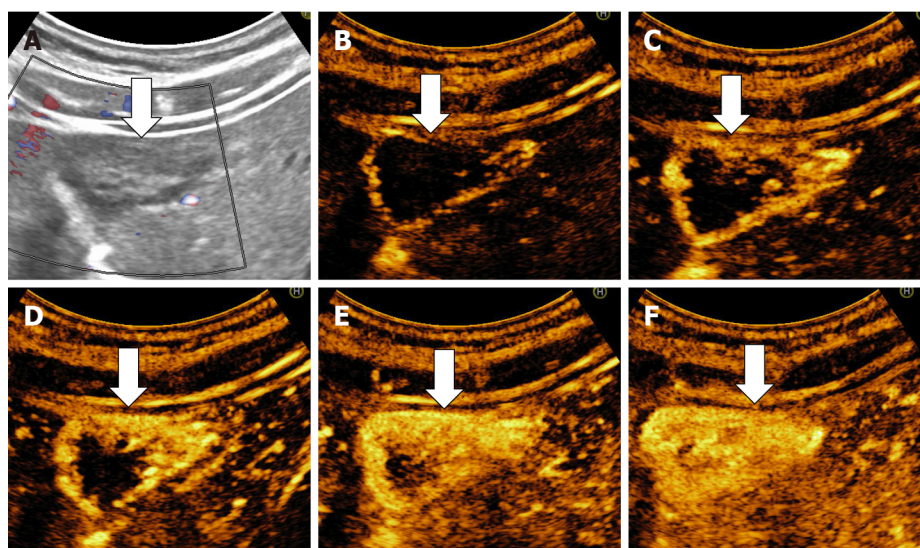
Example of hepatic hemangioma with inhomogeneous echogenicity. A: Gray scale ultrasound; B-E: On contrast enhanced ultrasound the hemangioma shows the typical peripheral nodular contrast enhancement (B and C) and centripetal fill-in (D and E); F: The mass shows strong homogenous enhancement in the late phase.
